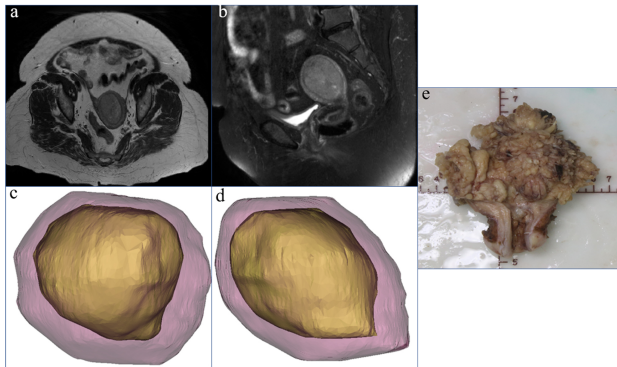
A 53-year-old female patient, preoperative MRI showed both axial (a) and sagittal (b) deep myometrial invasion. 3D-MRI showed deep myometrial invasion (c,d). The uterine volume was 113623.07 mm³, the tumor volume was 50742.01 mm³, the TVR was 44.66%. The uterine surface area was 12287.16 mm², the tumor surface area was 7231.83 mm², and the TAR was 58.86%. Postoperative pathologically confirmed uterine middle-poorly differentiated endometrioid carcinoma, invading deep myometrium (e).
